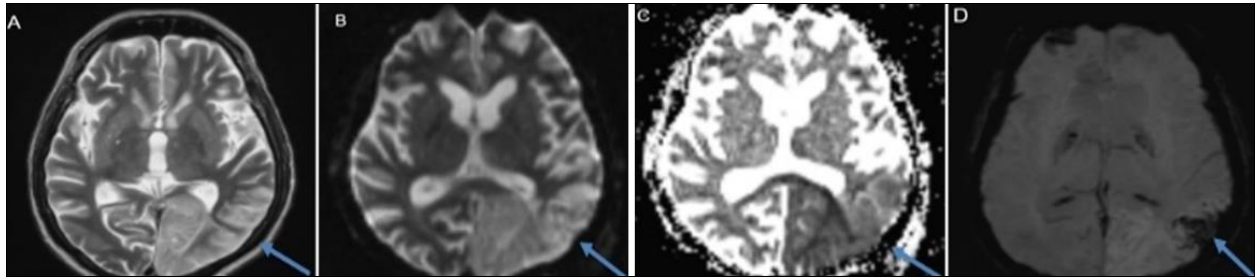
Different views of head MRI demonstrates acute middle and posterior cerebral artery stroke, axial T2 (A), axial DWI (B), axial ADC (C), and axial SWI (D)
